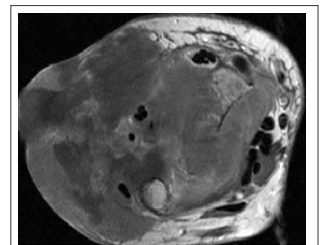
MRI - axial view of wrist (T1 weighted).
